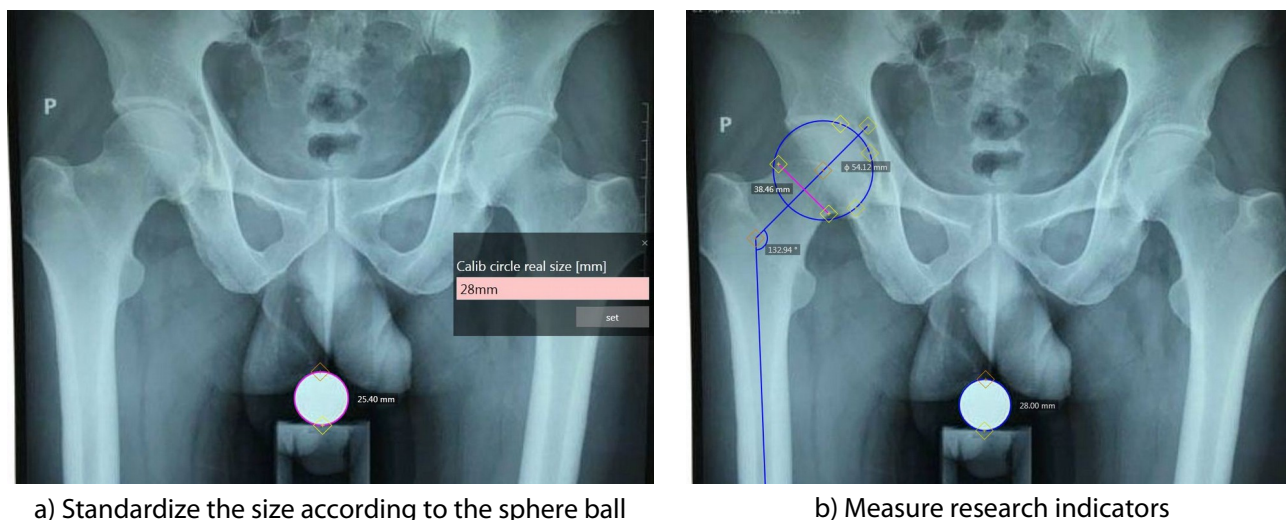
Measurement of research indicators based on X-ray film
